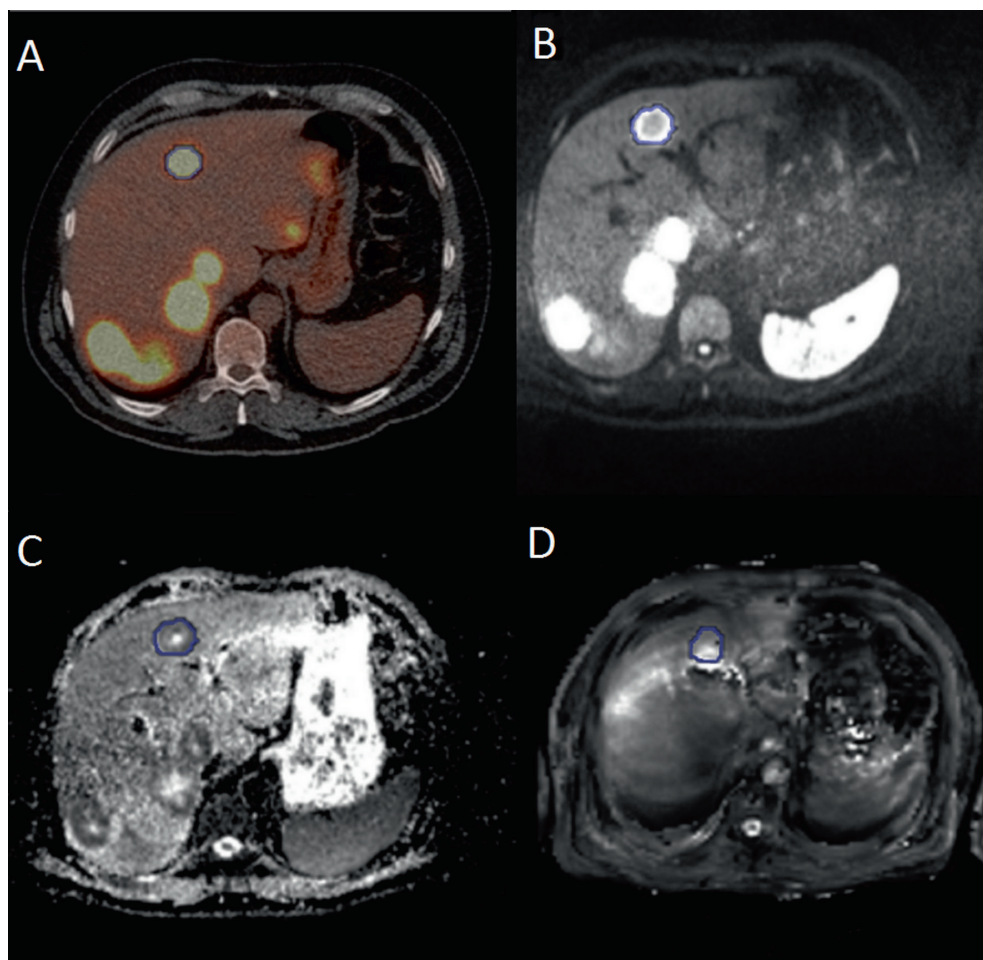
Typical images acquired with FDG PET, DWI and T2* of a patient with multiple liver metastases. One liver metastasis is delineated with a blue line on A) FDG-PET/CT B) a diffusion weighted image (b-value 50 s/mm²), C) ADC-map and D) T2*-map.
